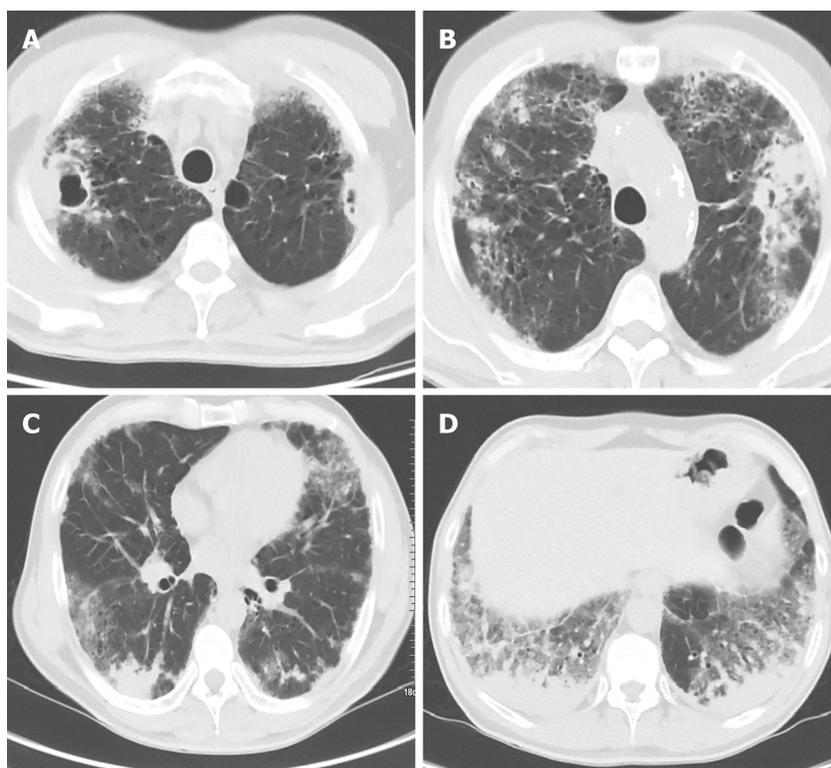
Chest computed tomography examination showing extensive multifocal and pleomorphic lesions in the lungs, including multiple pulmonary cavities, consolidation, ground-glass opacities, patchy infiltrates, fibrous bands, and large bullae. A and B: Upper lung; C: Middle lung; D: Lower lung.
